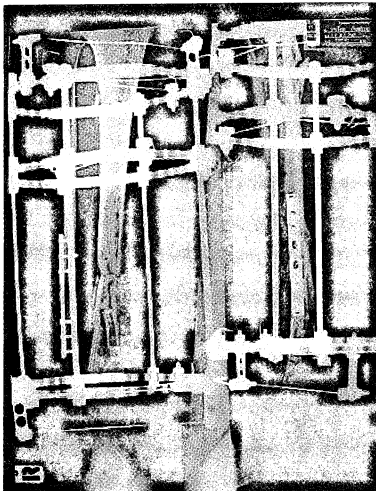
Anteroposterior and lateral roentgenogram of the tibia after ilizarov external fixator. The corticotomy was in the proximal part of the tibia.
